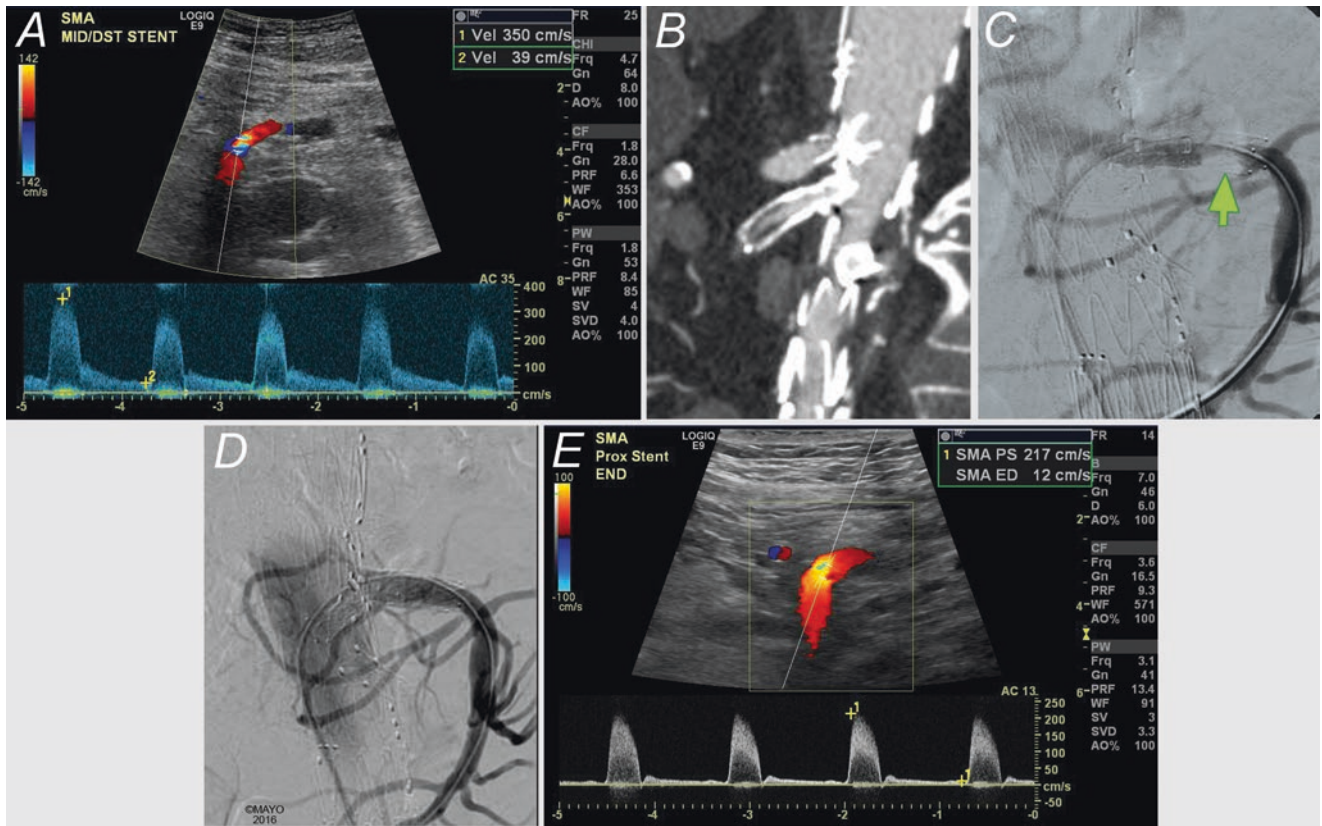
Duplex ultrasound of fenestrated endograft with a superior mesenteric artery stent showing elevated velocities consistent with in-stent stenosis (a). Correlation with CTA (b) and catheter angiogram (c) confirmed a significant stenosis. Angiogram post angioplasty and redenting shows resolution of stenosis with widely patent SMA stent (d) and normal velocities on ultrasound (e). By permission of Mayo Foundation for Medical Education and Research. All rights reserved
